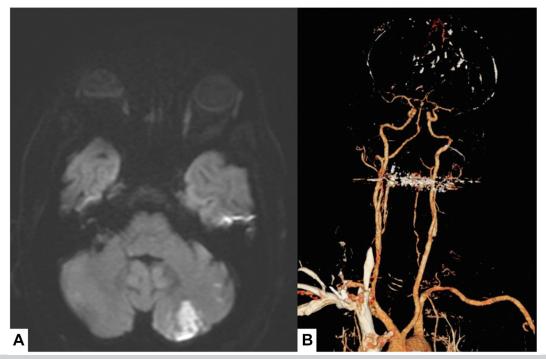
A, Diffusion-weighted magnetic resonance image showing left hemispheric cerebellar acute ischemic stroke. B, Computed tomography angiography (CTA) revealed a new occlusion of the V4 segment of the left vertebral artery (VA).
